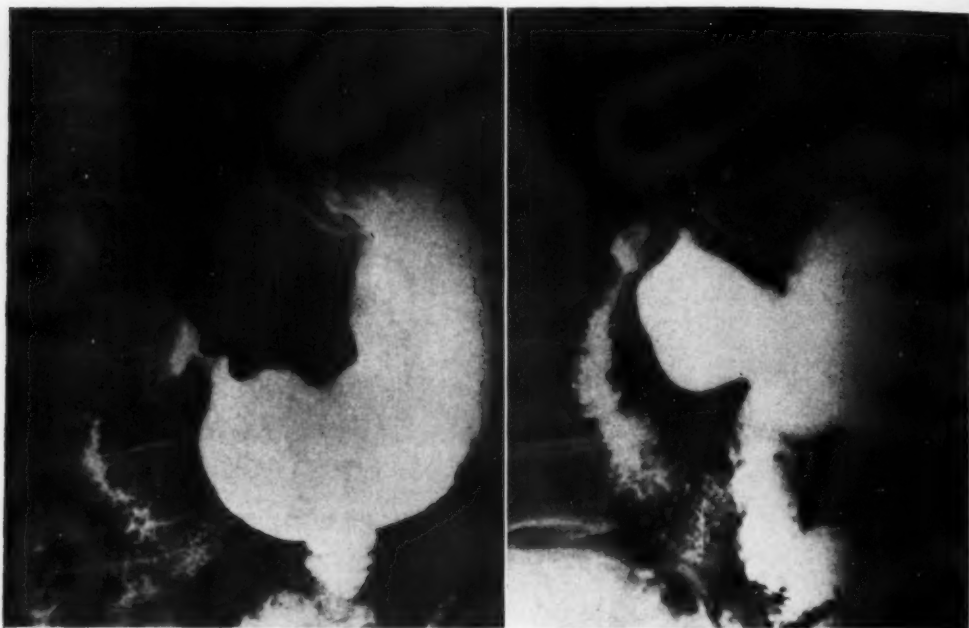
Case III. Roentgenogram interpreted as normal in a patient with diffuse antral carcinoma.
